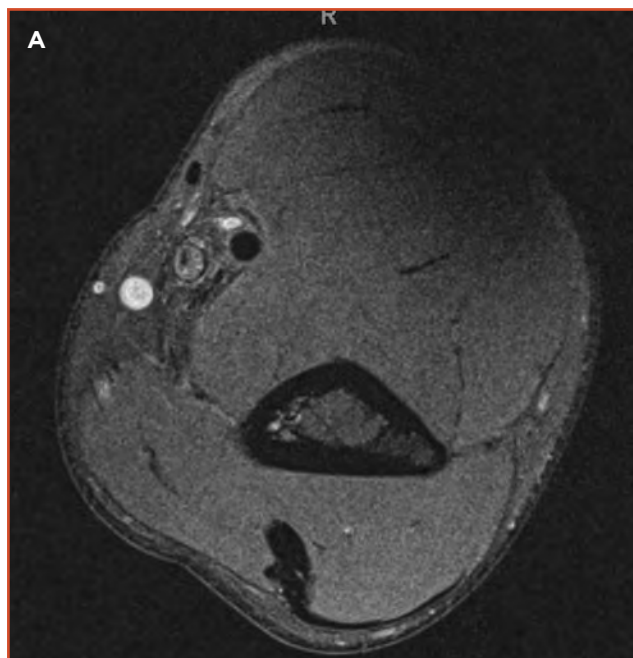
Axial view of magnetic resonance imaging of the arm through the zone of stenosis. A) Normal brachial artery girth proximal to the area of stenosis. B) Stenosed brachial artery.
